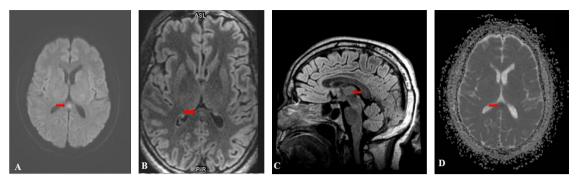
Initial MRI imaging showing an hyperintense signal in the SCC on DWI (A) and T2-FLAIR images (B, C) with reduced ADC value (D).
